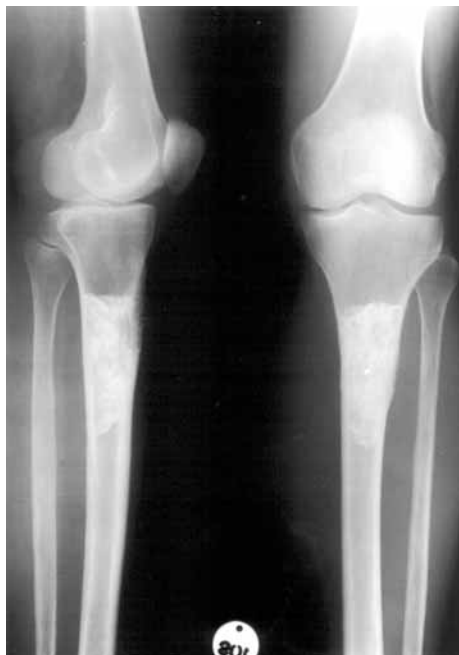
Radiographic appearance of HPC of the left tibia on admission.
